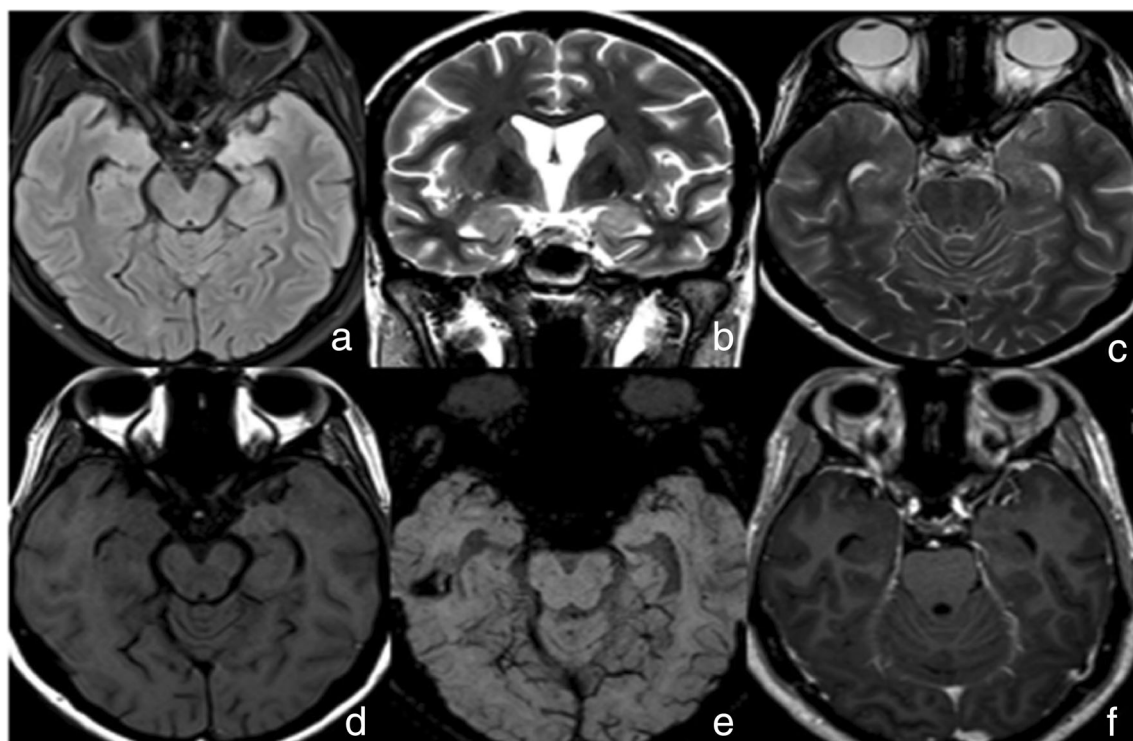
a, b, c, d, e, f represent FLAIR, T2WI, T1WI, SWI, and post-contrast MPRAGE images. They show hyperintense signal changes on T2WI and FLAIR images and isointense on T1WI involving the left
